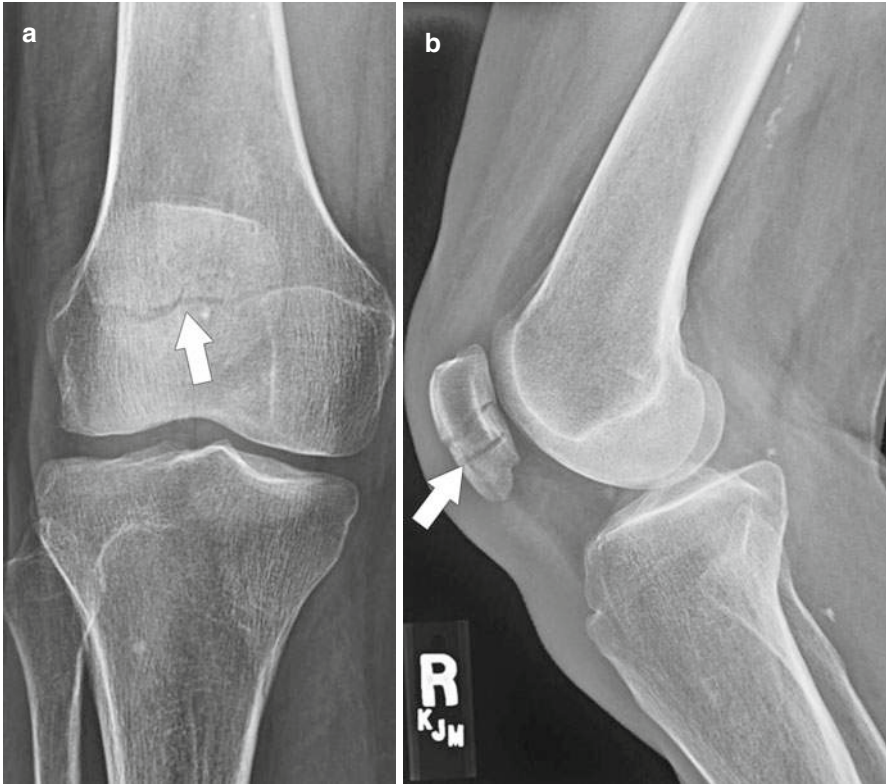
Patellar fracture. Knee X-ray posteroanterior (a) and lateral (b) views reveal a transverse patellar fracture (*arrows*)
